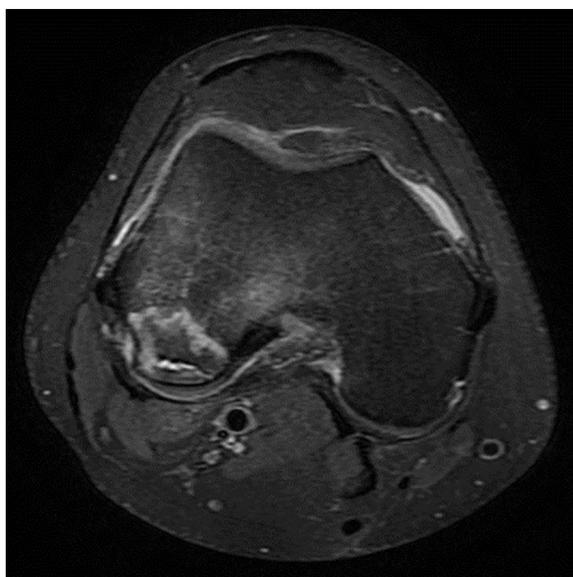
Axial proton density MRI with fat saturation showing insufficiency fracture with associated marrow edema in posterior non-weight-bearing zone of lateral femoral condyle in a 67-year-old female.
